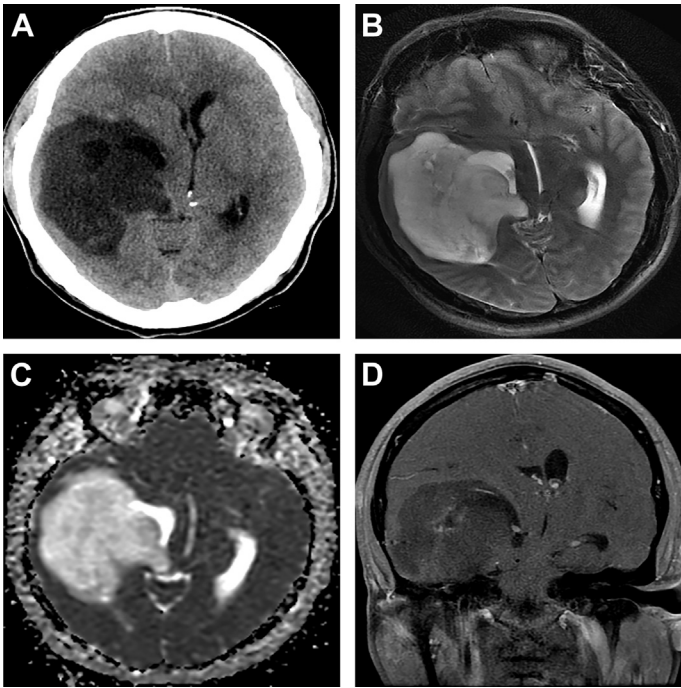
IDH-mutant glioblastoma. A 53-year-old woman who presented with generalized fatigue and constitutional symptoms. Axial CT scan (A) shows a large mass in the right temporal lobe with severe mass effect on the surrounding brain parenchyma and midline shift to the left. Axial T2 image (B) shows large, well-defined hyperintense mass lesions without surrounding edema and high ADC value (C). Post-contrast coronal T1-weighted image (D) shows mild enhancement in the central portion of the tumor with severe mass effect on the brainstem and midline shift of 11 mm.
